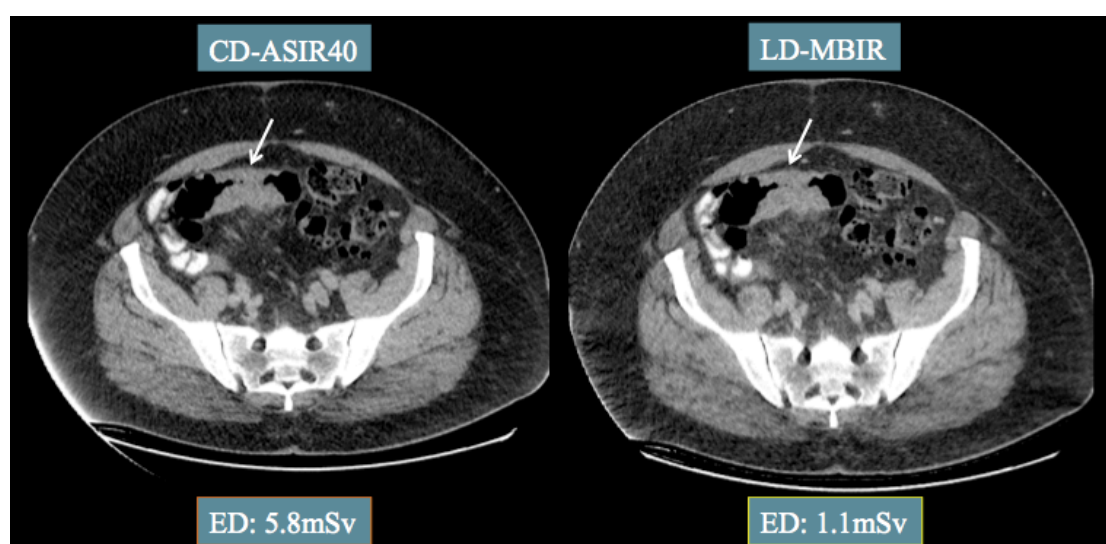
CD-ASIR and LD-MBIR axial CT images in a 56 year-old female patient presenting with acute abdominal pain demonstrate a short segment of sigmoid colonic wall thickening with adjacent inflammatory changes.
